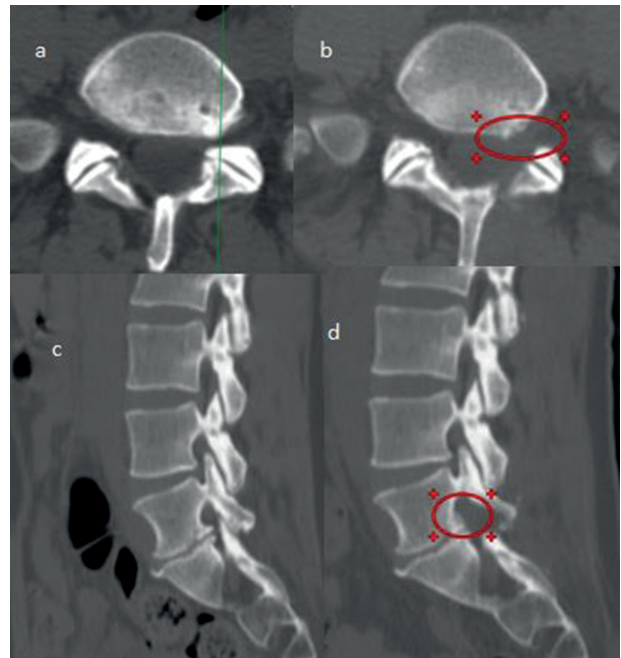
a) Osteophyte formation can be observed in the L5 left foramen. b) Postoperative axial image shows decompression, indicating that the foramen was expanded. Decompression was performed with hemilaminectomy and osteophyctomy. Osteophytic spur can be seen at the medial side of the vertical red line (a) which cross from the anterior point of articulation faces of facet joint. Therefore, the facet joint could be protected. Preoperative (c) and postoperative (d) sagittal computed tomography images also showed differences after surgical treatment. The patient's complaint of left leg pain dramatically decreased after surgery
